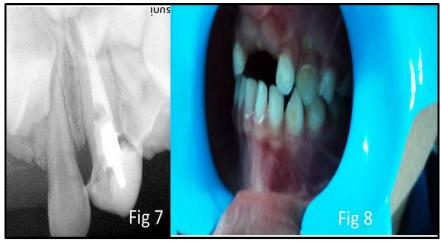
follow-up radiographs and photographs at 12 months interval
